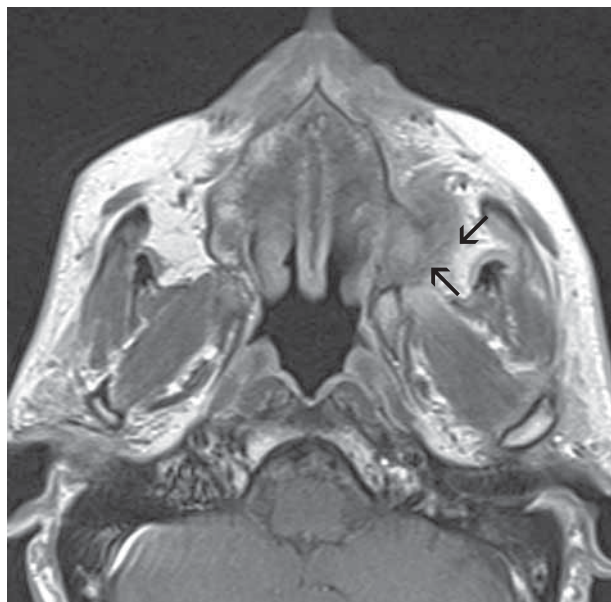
Axial contrast-enhanced T1-weighted image shows squamous cell carcinoma of the gingival maxilla and hard palate. Involvement of branches of the superior alveolar nerve by the tumor (black arrows) is shown, which caused facial pain on the left side.
